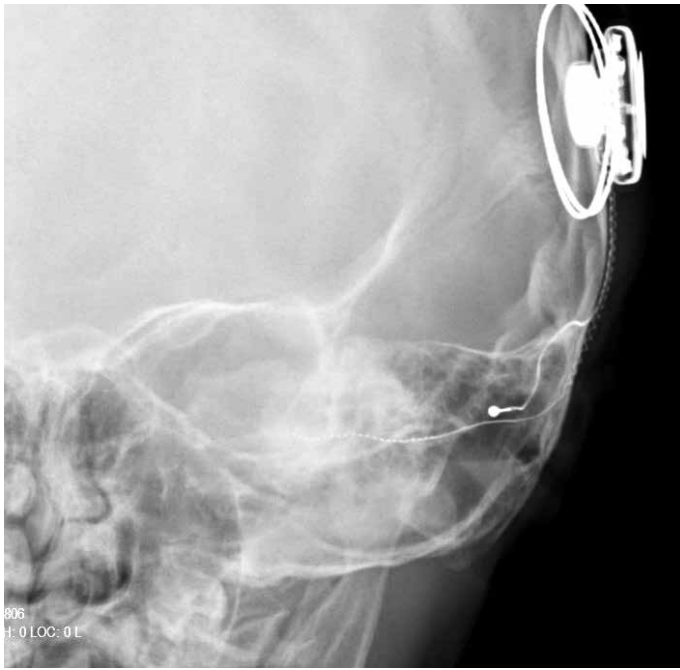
X-ray graph of the patient in whom the electrode does not rotate along the cochlea.
